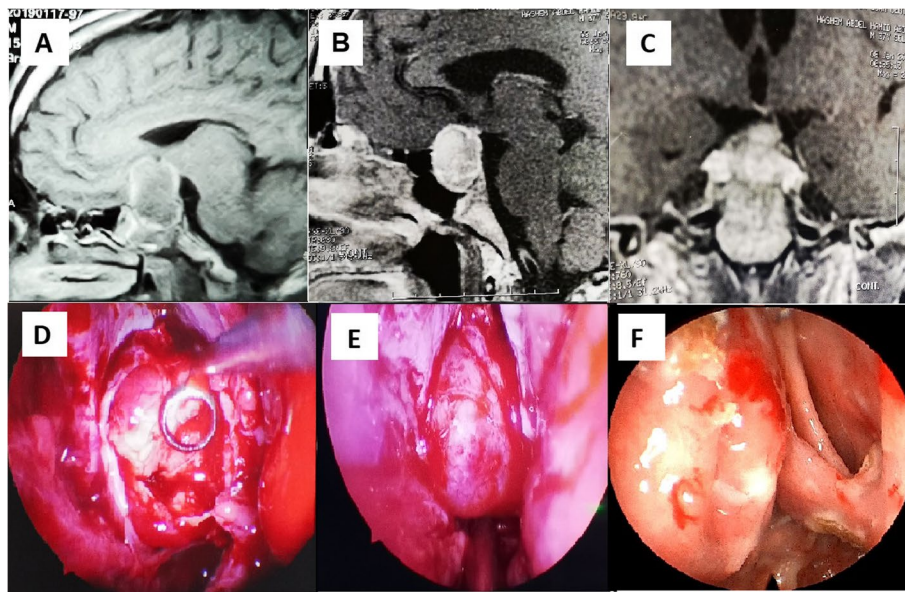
A 24-year-old male patient with a pituitary macroadenoma: A sagittal T1 pre-contrast MRI image, B sagittal T1 post-contrast MRI image, and C coronal T1 post-contrast MRI image showing an intensely enhanced pituitary macroadenoma with a suprasellar extension. D Intraoperative endoscopic view revealing the exposed pituitary adenoma after opening the sellar floor. E An intraoperative endoscopic view showing the covered skull base defect with a nasoseptal flap. F A 1-month postoperative endoscopic view showing the healed nasoseptal flap with minimal crusting
